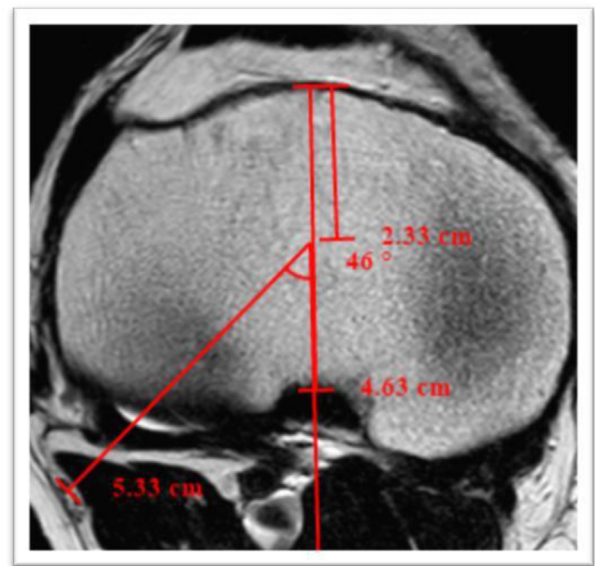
T2 weighted magnetic resonance image at the level of tibial bone cut, showing angle of CPN with respect to tibial centre and relationship of the CPN to the popliteus tendon from the center of the tibia. In this case, CPN was in line with the popliteus tendon.
